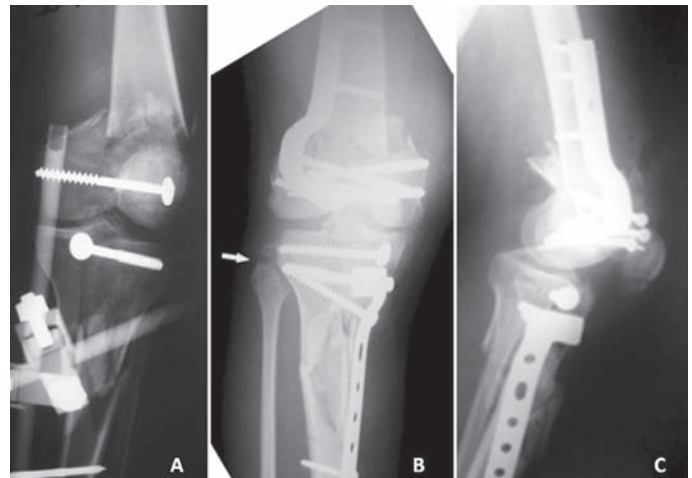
X-ray controls for clinical case nr. 2: (1-A) X-ray image at AP plane: temporary early stabilization with tubular external fixator and minimal osteosynthesis with spongy screws and washers for reducing femoral and tibial joint surfaces. (1-B) X-ray image at AP plane: permanent synthesis and detail of the fibular head bone avulsion (arrow) and (1-C) X-ray image at lateral plane: permanent synthesis.
